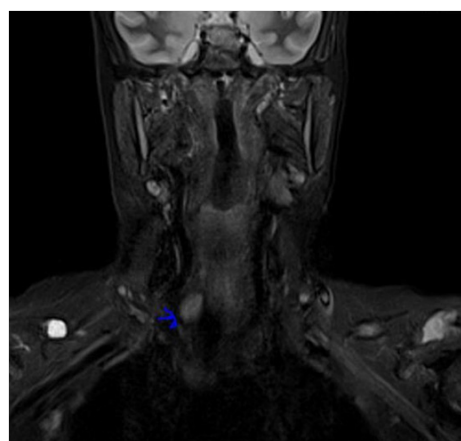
T2FS coronal MRI of neck showing hyper-intense parathyroid adenoma at the lower pole right thyroid gland.
